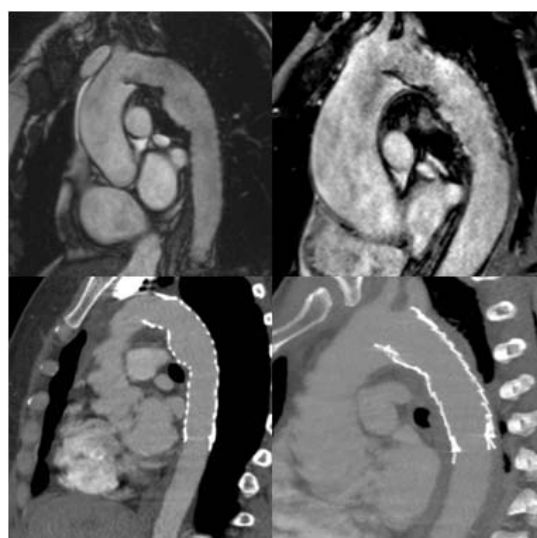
Appearance of the thoracic stent in MRI (top) and CTA (bottom).
